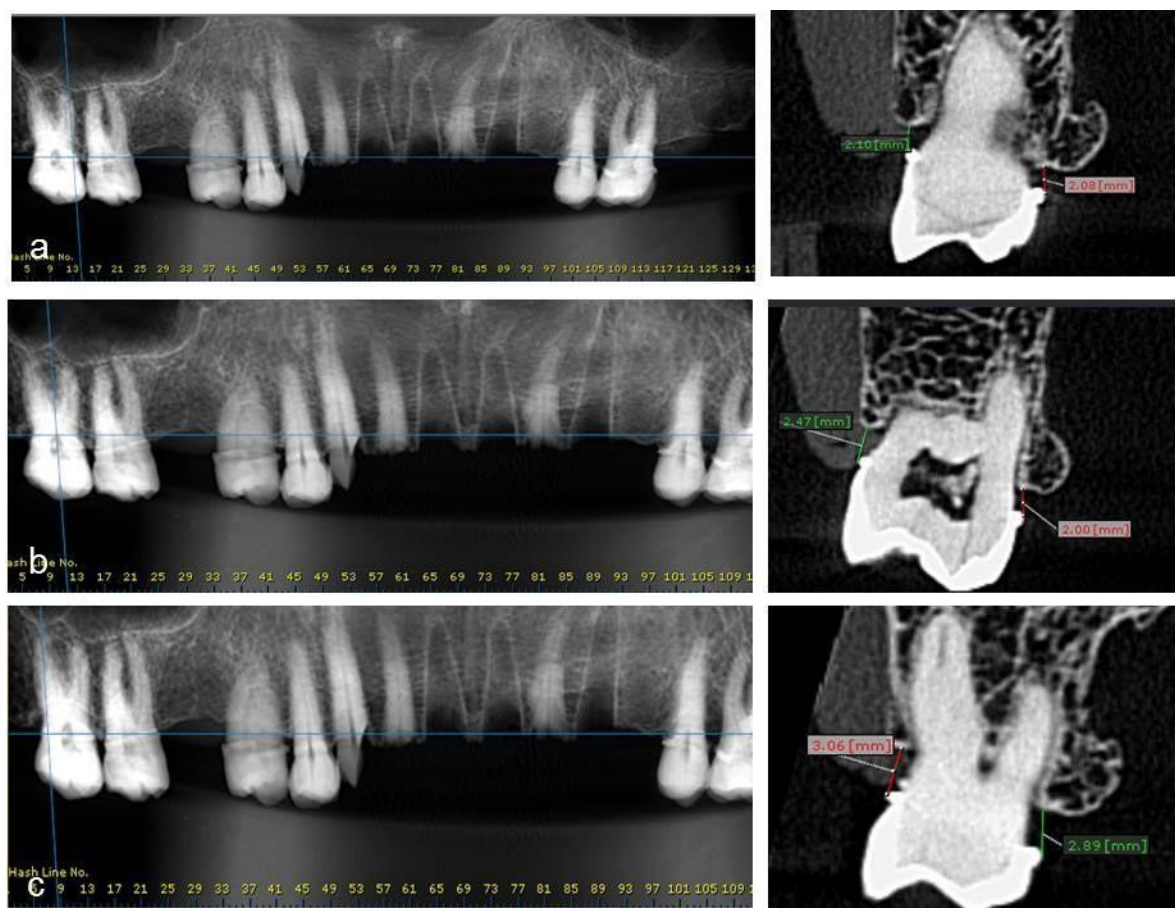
CBCT Reconstructed panorama and cross sectional cuts showing linear measurements; a: at mesiobuccal and mesiopalatal points at the mesial aspect, b:atmidbuccal and midpalatal points in the middle and c: at distobuccal and distopalatal points at the distal aspect of upper right third molar.
